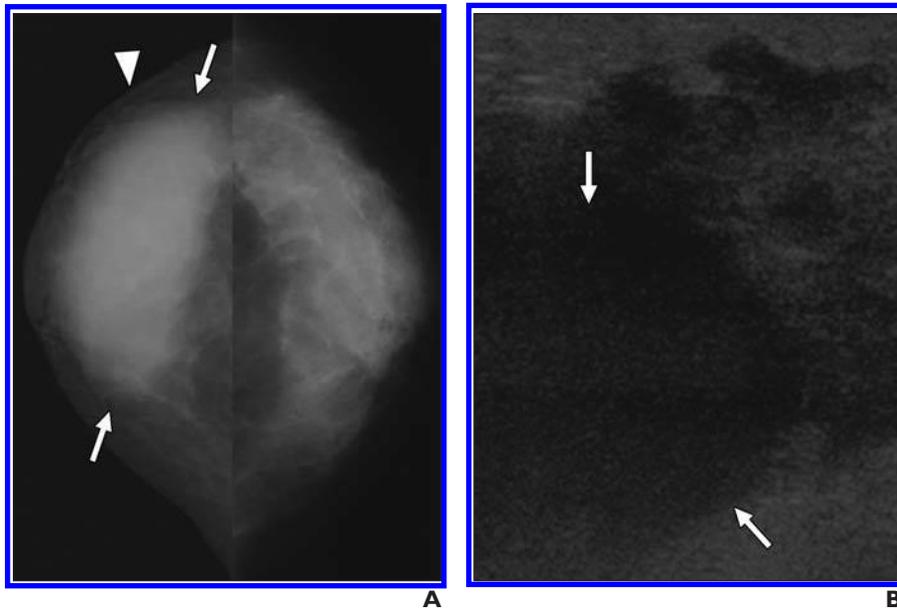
33-year-old lactating woman presenting with inflammation and palpable mass. A, Mammogram reveals asymmetric density (arrows) within right breast with overlying skin thickening (arrowhead). B, Corresponding ultrasound shows solid irregular hypoechoic mass (arrows). Palpation-guided core needle biopsy revealed inflammation consistent with mastitis which resolved with treatment.
